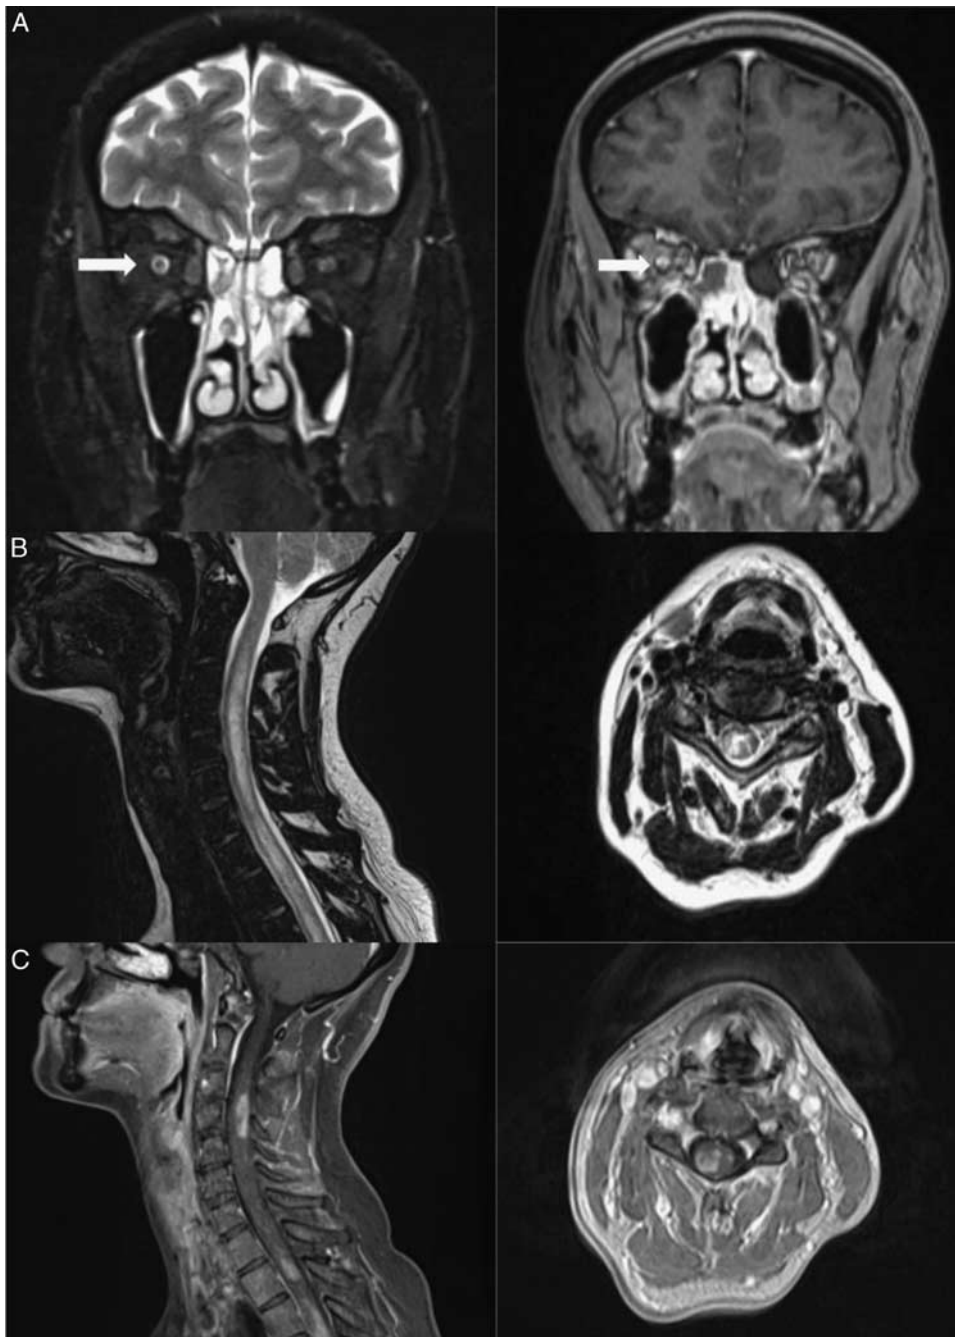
The T2-hyperintense (left), contrast enhanced (right) right optic nerve on axial brain MRI, consistent with optic neuritis (A). Arrows indicate the anatomical location of right optic nerve, which has the pathological MRI changes as described. Sagittal and Axial T2-weighted (B) and T1-weighted (C) cervical MRI images performed during the second attack demonstrating a T2-hyperintense longitudinally extensive spinal cord lesion with patchy contrast enhancement. MRI indicates magnetic resonance imaging.
